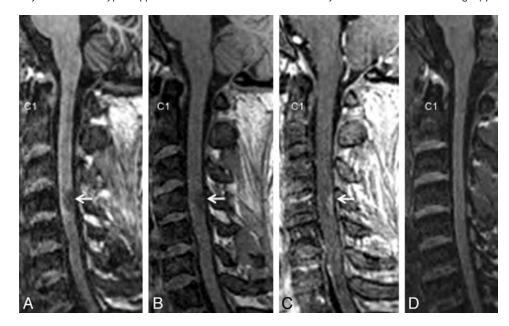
An acute spinal cord lesion in the C4 region (*arrow*, 31-year-old man) as seen in T1-MPRAGE (*A*), precontrast (*B*), and postcontrast (*C*) T1-weighted gradient-echo (*C*) images. (*D*) T1-MPRAGE from a healthy control participant (38-year-old man) for comparison.
